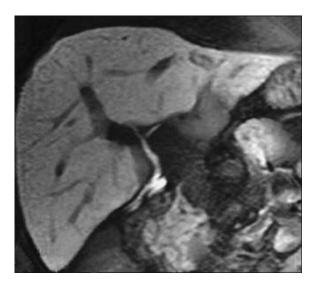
Bilio-enteric anastomosis in liver transplant patient. Coronal MIP 3D mangafodipir-trisodium-enhanced T1-weighted MR cholangiogram permits both morphological and functional evaluation of the bilio-enteric anastomosis. No complication is present in this case
